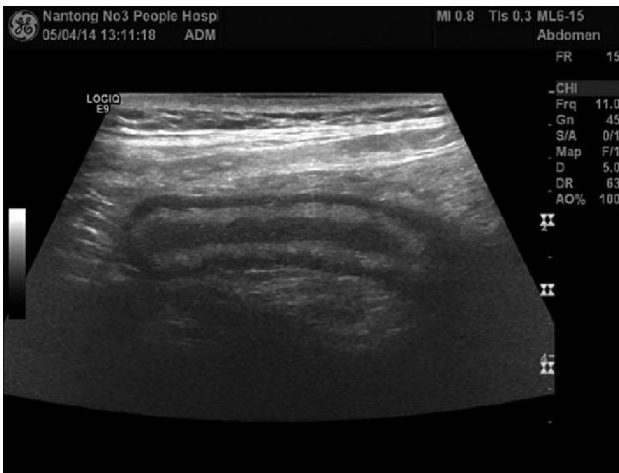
Ultrasound image showing dilated appendix.
